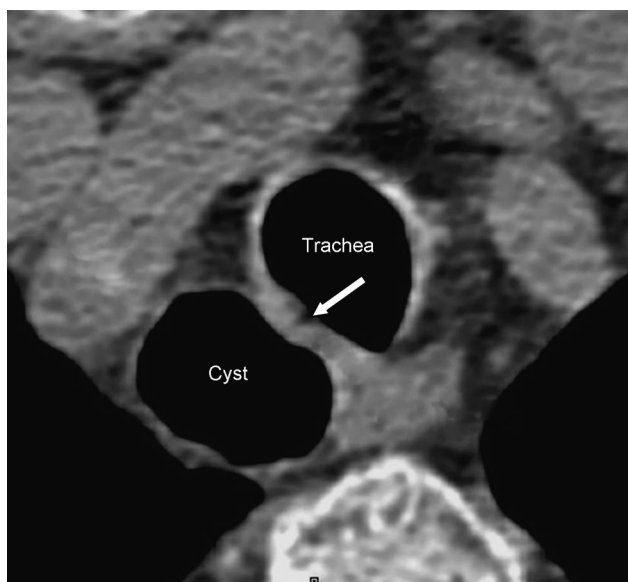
Axial computed tomography scan of the thorax shows an air cyst in the right aspect of the trachea, with connection to the trachea (arrow).
